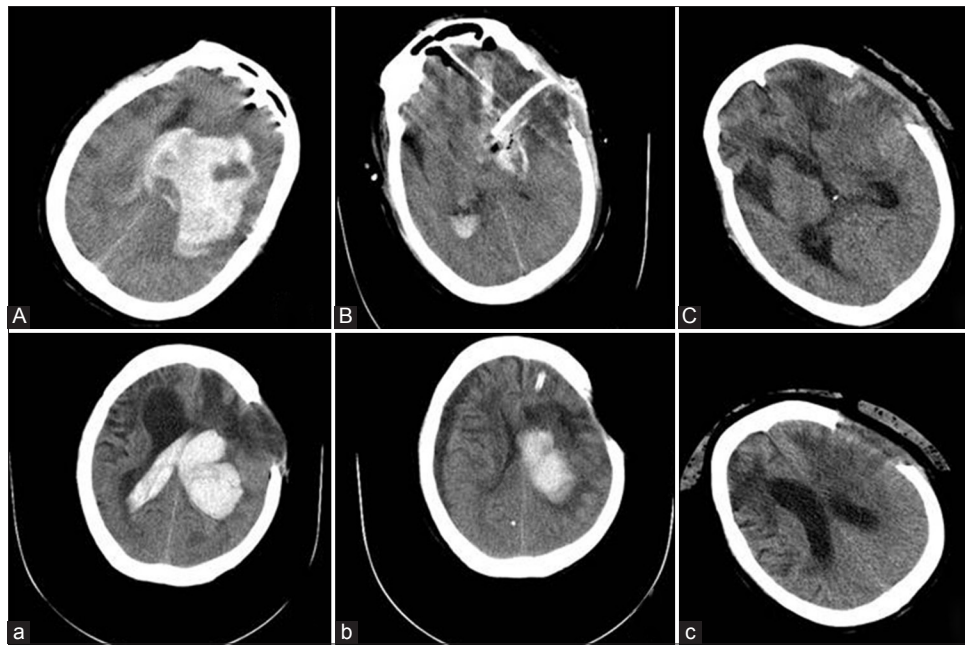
Computed tomography images of a patient who underwent both the craniotomy and the Fast-D treatment. (A) Left basal ganglia hemorrhage (165 ml) before craniotomy; (B) Two days after craniotomy; (C) One month after craniotomy; (a) Left basal ganglia hemorrhage (103 ml) (2 years later); (b) Two days after Fast-D drainage treatment; (c) One month after Fast-D treatment
